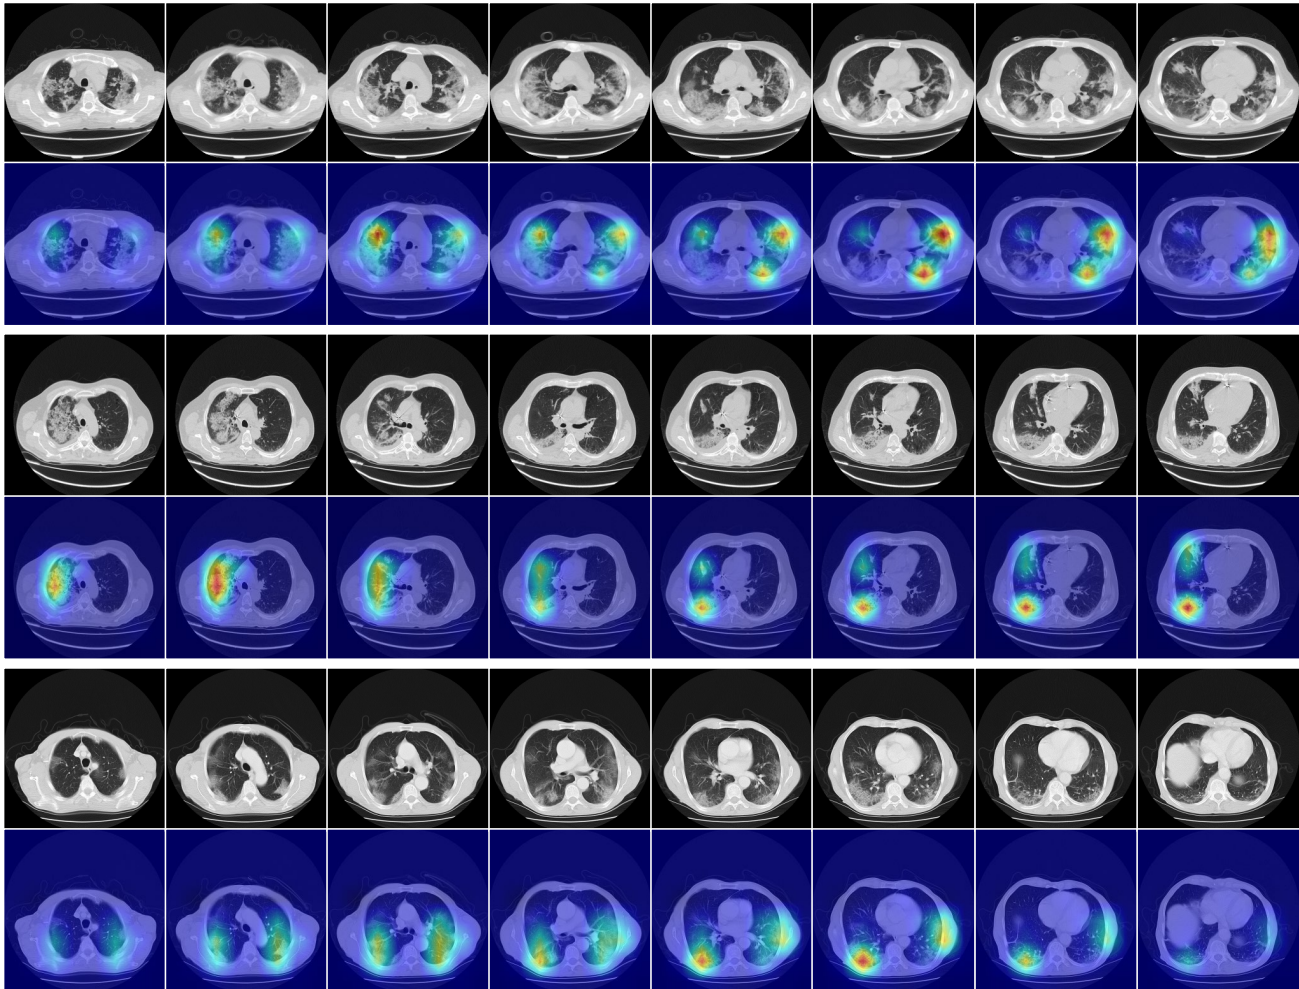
CAM visualization results on COVID-19 CT scans.
